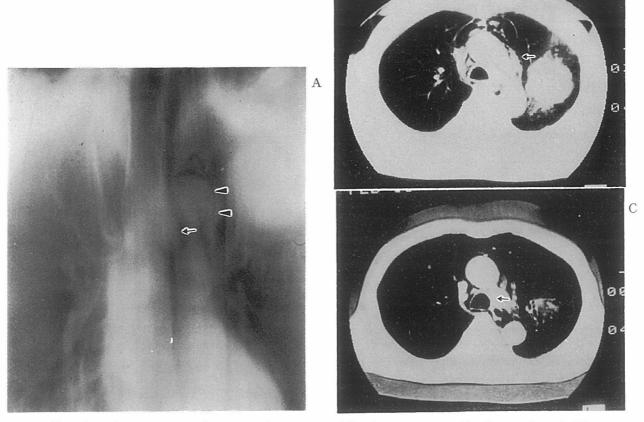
Filtered tomogram and computed tomogram following pneumomediastinography. A 73-year-old man with mediastinal lymph node metastasis from renal cell carcinoma.
